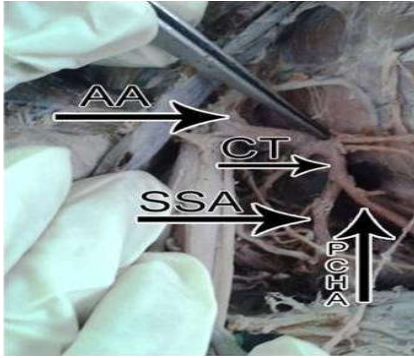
Showing Sub Scapular artery (SSA), Posterior Circumflex Humeral Artery (PCHA) arising from third part of axillary artery (AA) as Common Root (CT).
